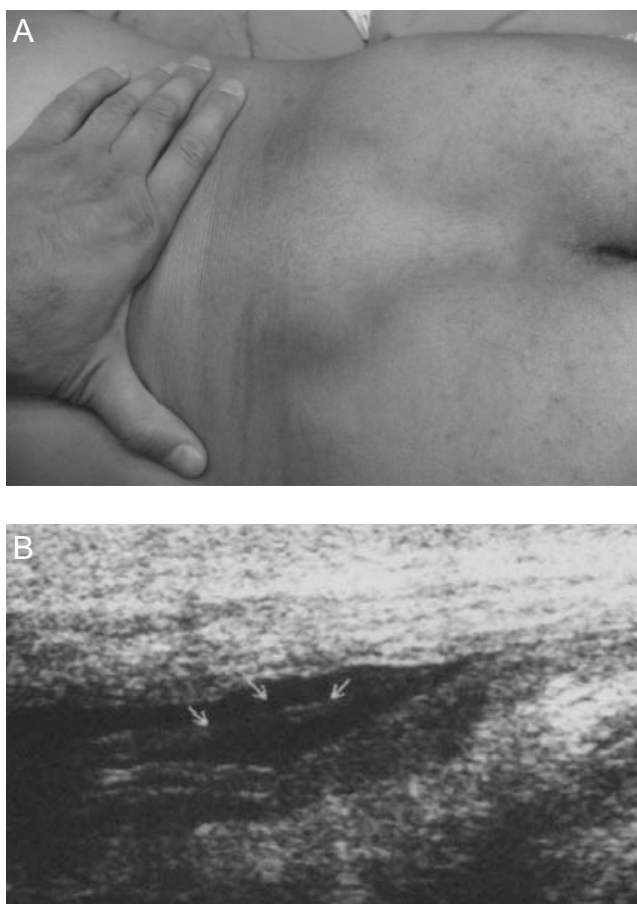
(A) Effusion in the lumbar region of the patient. (B) A hollow object is seen on ultrasonographic examination.
